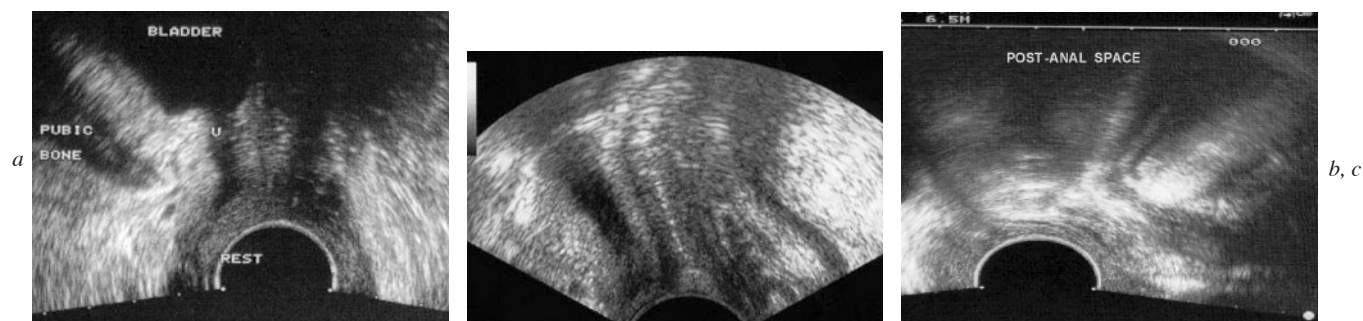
Transperineal sonographic technique: with the transducer positioned on the sagittal scanning plane just under the symphysis pubis (position one) the typical appearances of the bladder, urethra and urethro-pubic ligaments are displayed (a); moving probe handle anteriorly (position two), permits inclusion of the vaginal canal, utero-vesical junction and Douglas pouch (b) within ultrasound beam. When transducer handle is moved even further anteriorly so that a vertical position (position three) is reached the end of transducer points more caudally and the anorectum is depicted together with the post-anal space (c).
